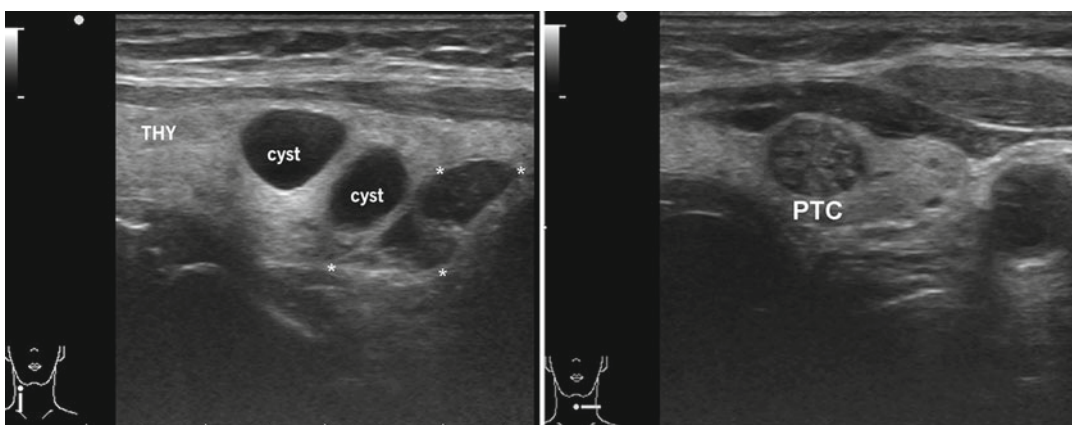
Co-existing thyroid disease with primary hyperparathyroidism. The sonographic image depicts two intrathyroidal cysts and an enlarged right inferior
